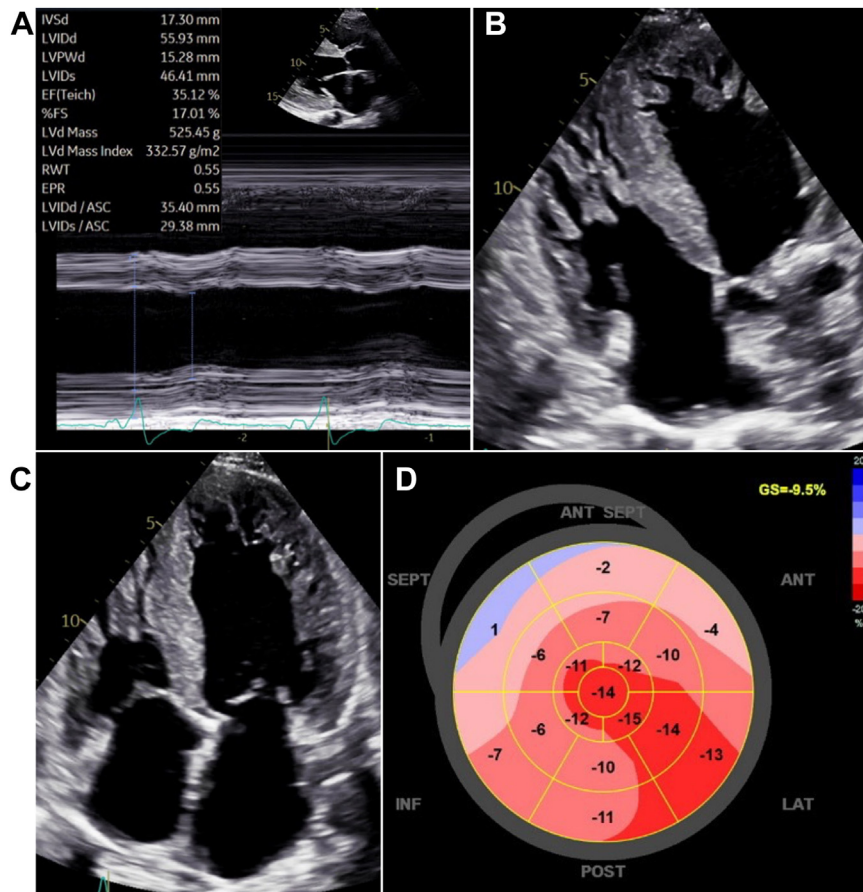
Transthoracic echocardiographic study. (A) M-mode measurement of the left ventricle shows a maximum thickness in the basal septum of 17 mm. (B) Hypertrophied right ventricle. (C) Hypertrophied and dilated left ventricle. (D) Bull's eye plot of global longitudinal strain.
